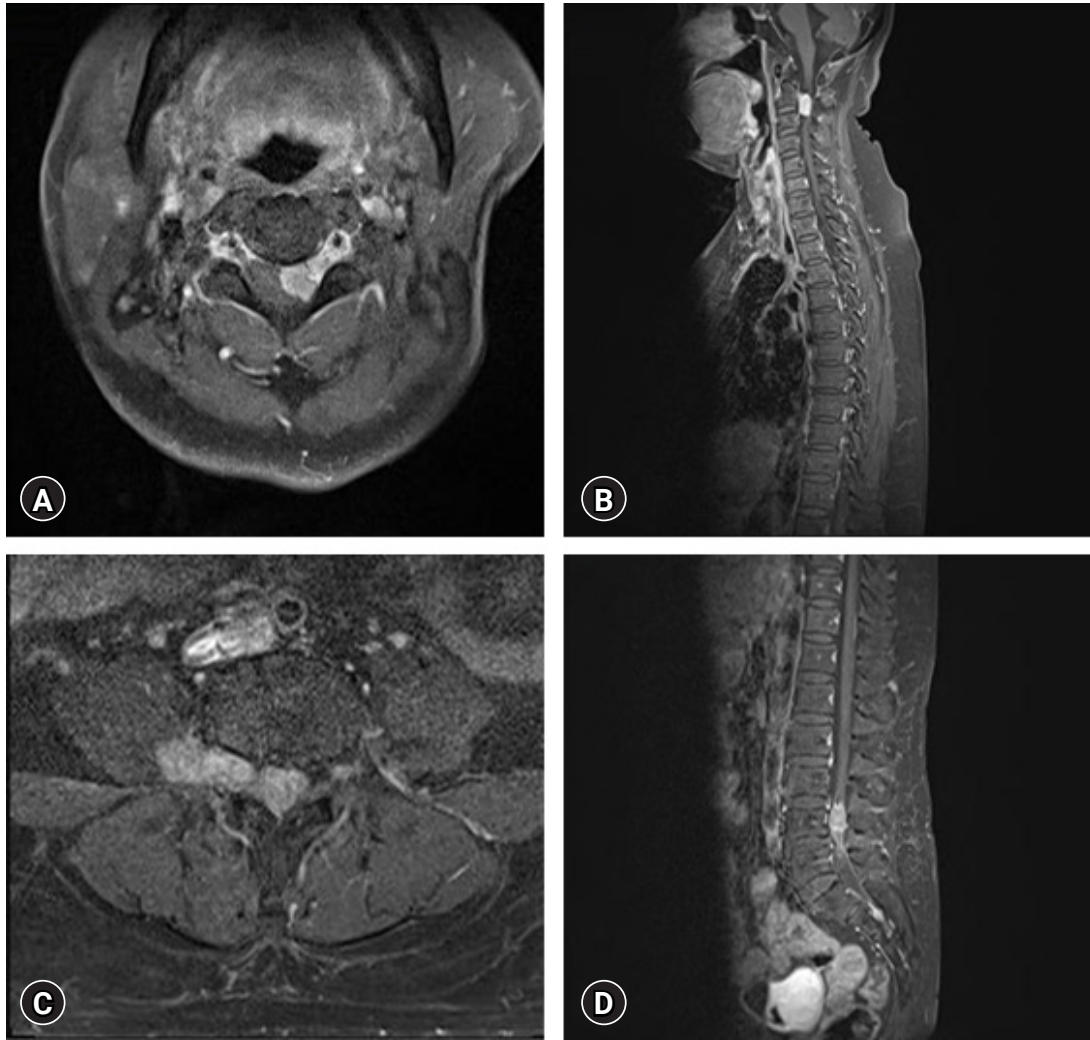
Magnetic resonance images shows a homogeneously enhanced mass with suspected metastasis in the left extradural space at the C2-3 level and the right extradural space at the L3-4 level. T1-weighted axial and sagittal images with gadolinium enhancement. (A, B) Cervical lesion. (C, D) Lumbar lesion.
